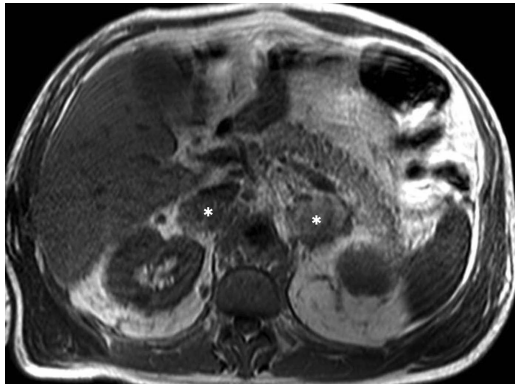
Axial T1-weighted MRI showing bilateral adrenal metastases (asterisks).
